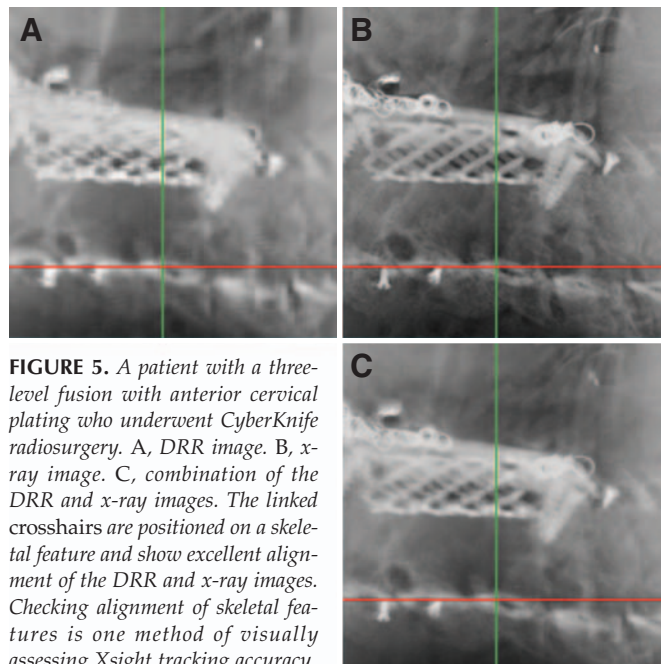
A patient with a three-level fusion with anterior cervical plating who underwent CyberKnife radiosurgery. A, DRR image. B, x-ray image. C, combination of the DRR and x-ray images. The linked crosshairs are positioned on a skeletal feature and show excellent alignment of the DRR and x-ray images. Checking alignment of skeletal features is one method of visually assessing Xsight tracking accuracy.
